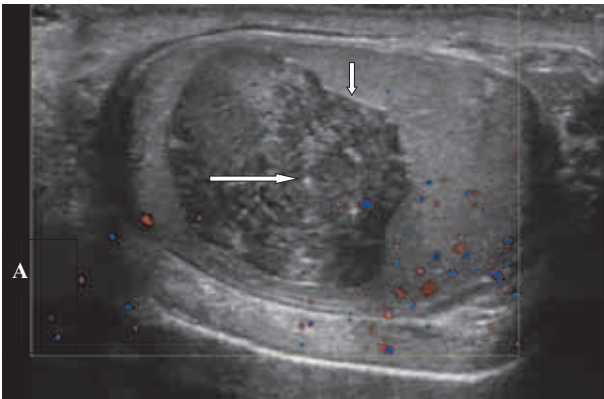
Scrotal ultrasonography showing a sharply defined mass with a hyperechoic rim and an onion-peel appearance (short arrow). A “target/bull’s eye” pattern can also be observed in the center of the mass (long arrow). (Retrospective review).
